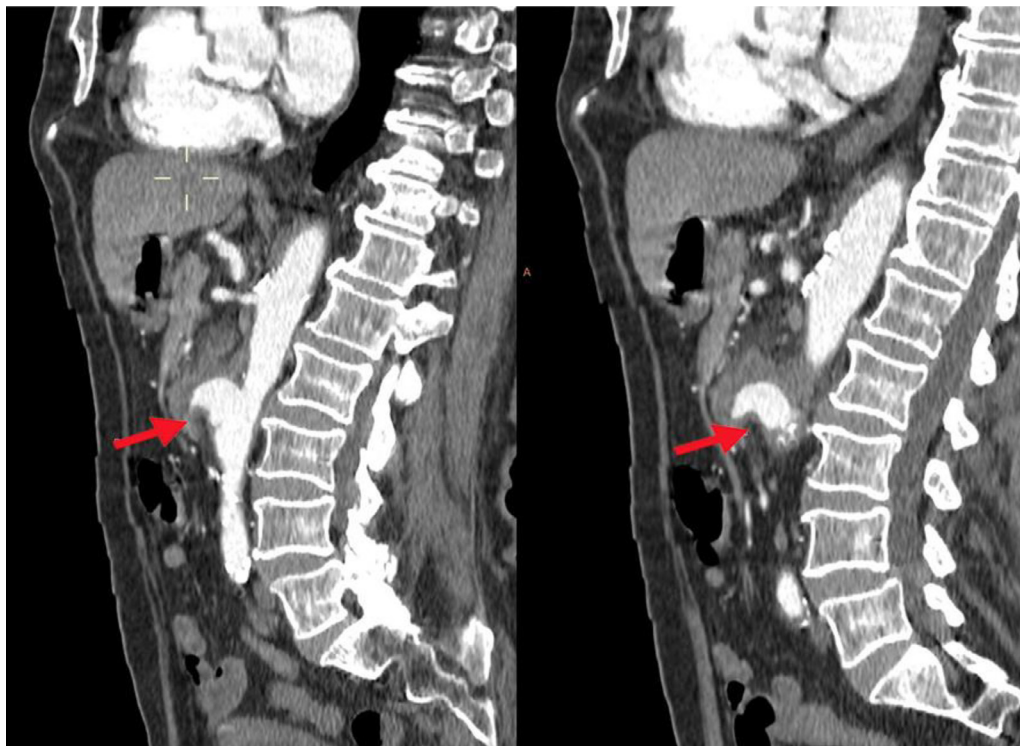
Coronal computed tomography with contrast images (Arterial phase) showing disruption of the aortic wall and extravasation of aortic contrast to the intestinal lumen associated to a focal thickening of the duodenum wall.
